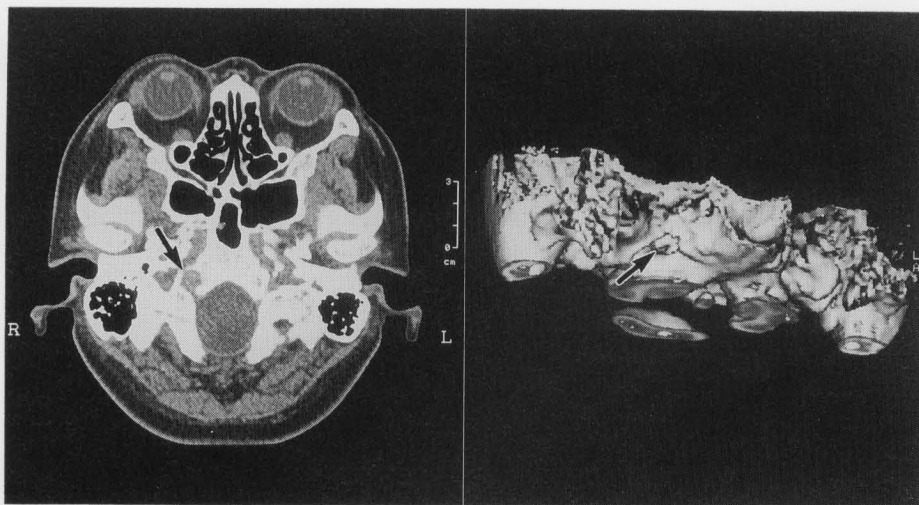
The skull-base CT shows a markedly dilated right hypoglossal canal and erosive change involving the clival edge (arrow). The three-dimensional CT shows that the tumor arises from the external orifice of the right hypoglossal canal (arrow).
